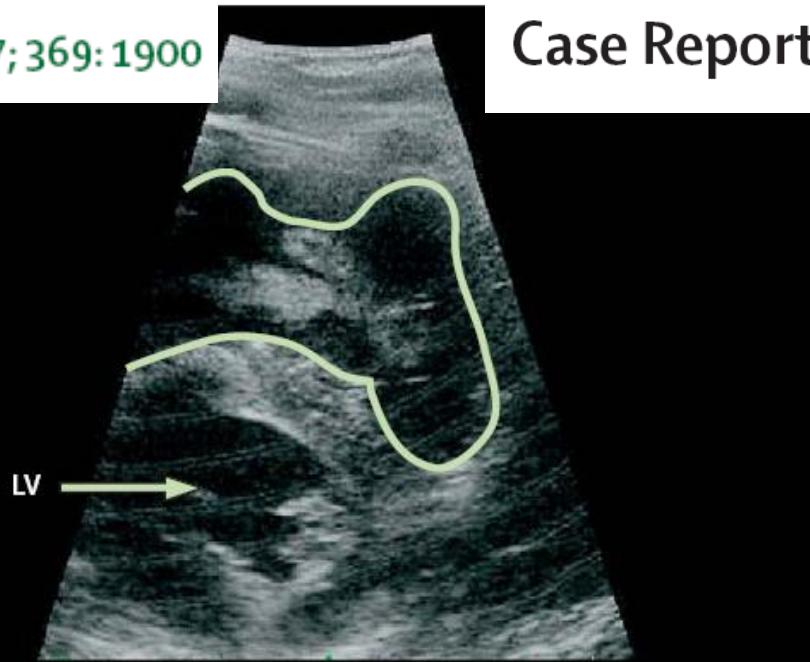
Echocardiography, showing AFE
